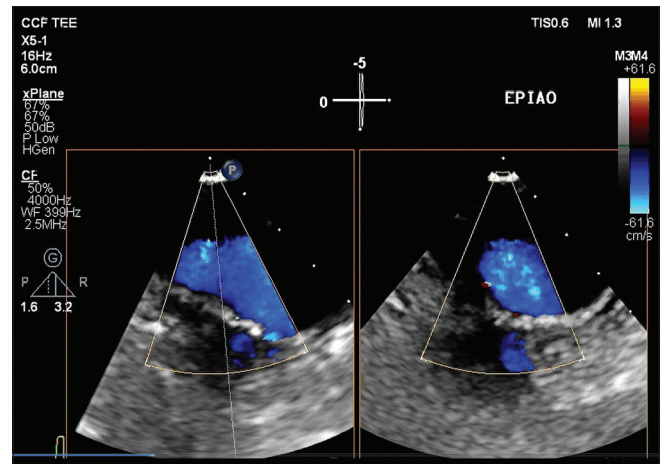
Epiaortic echocardiography using Multiplane and Color Flow Doppler. Demonstrates systolic flow in the graft at the arch level and presence of color artifact in the suture line and wall
